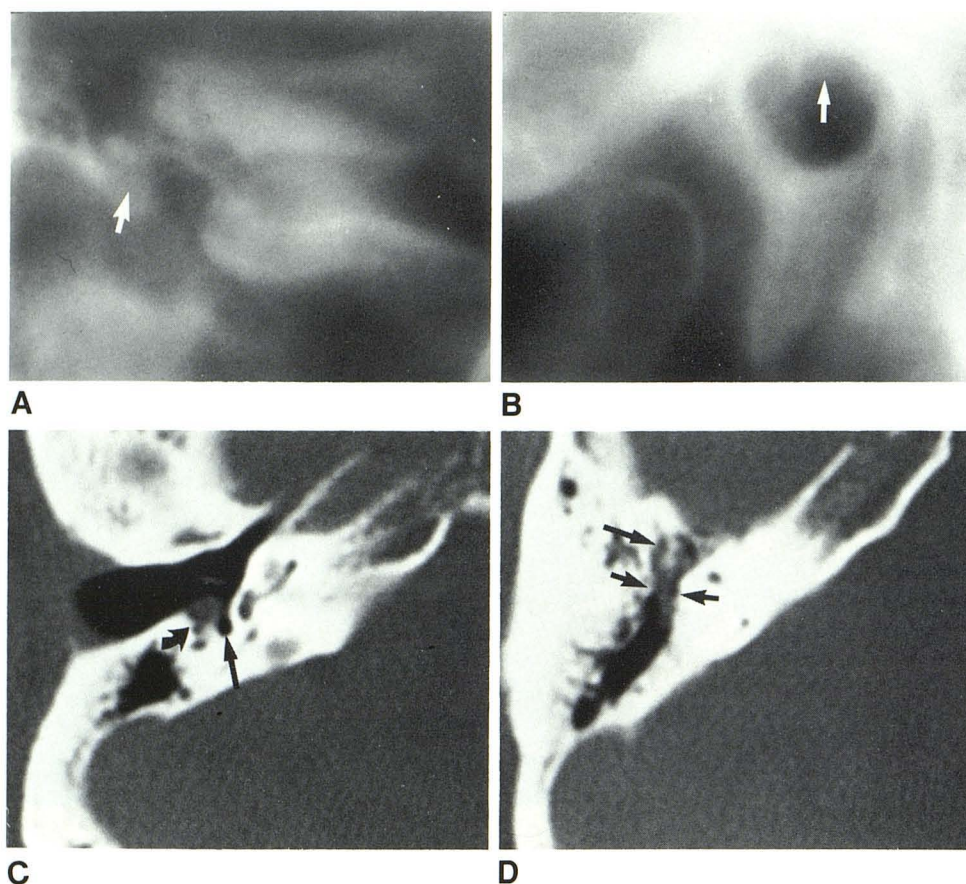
Young man with right cholesteatoma who had previous left radical mastoidectomy. A, Coronal tomogram at oval window level. There is poorly defined soft-tissue mass in middle ear (arrow). B, Sagittal tomogram at level of malleus and incus. Long process of incus is eroded (arrow). C, Axial CT scan through inferior middle ear. Cholesteatoma is in facial recess (curved arrow) but not in sinus tympani (straight arrow). Long process of incus has been eroded. D, Axial scan 6 mm higher than C. Soft-tissue density of cholesteatoma surrounds top of malleus and incus (long arrow) and extends posteriorly into narrow aditus (short arrows). Posteriorly, antrum is clear.
